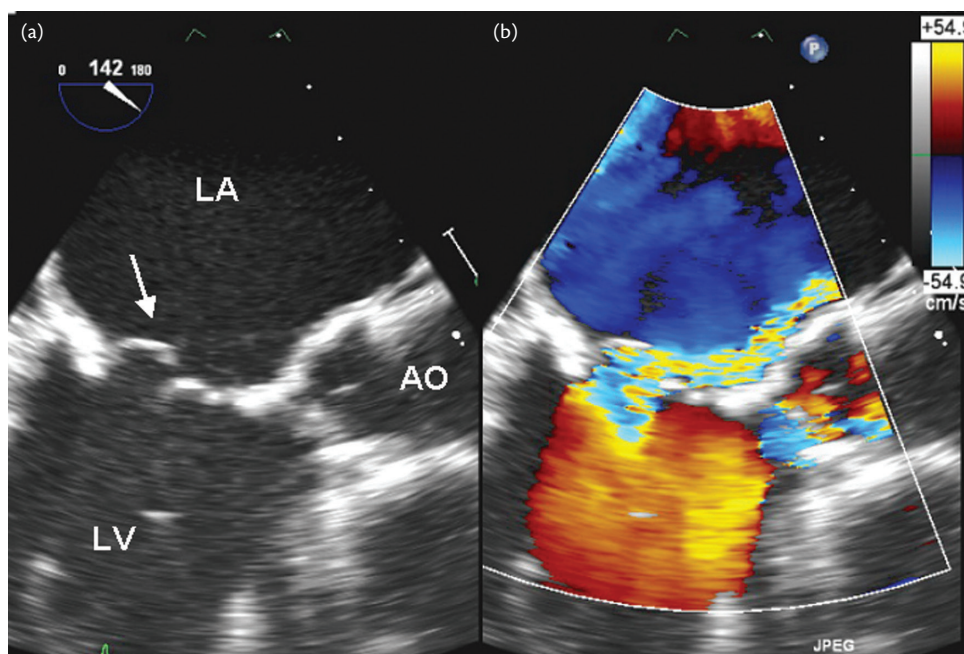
Transoesophageal echocardiography in MR. (a) Severe mitral valve prolapse with a flail of posterior leaflet (P2 segment) (arrow). (b) Colour flow imaging showing severe MR with an eccentric jet directed in the opposite direction to the prolapse segment. Ao, aorta; LA, left atrium; LV, left ventricle. Courtesy of Dr E. Brochet.
